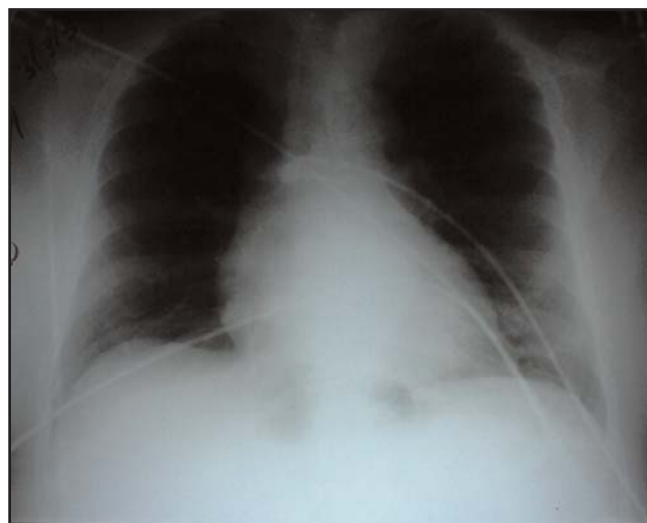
William's chest X-ray.
